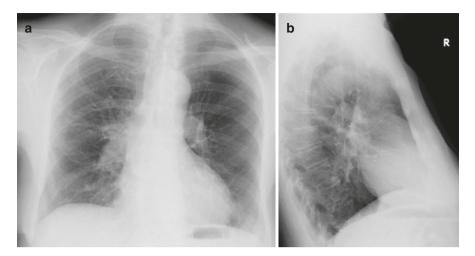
(a) Posteroanterior chest X-ray: strip-like to cloud-like shadows in the right lung. The left lobe shows normal transparency. (b) Lateral chest X-ray: patchy shadows in the upper lobes
